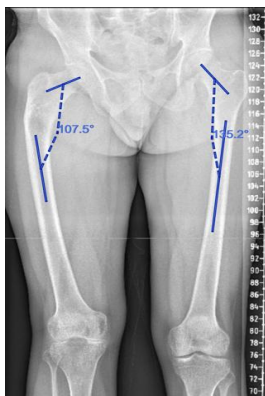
Preoperative radiograph revealed varus malunited femur with shortening.
